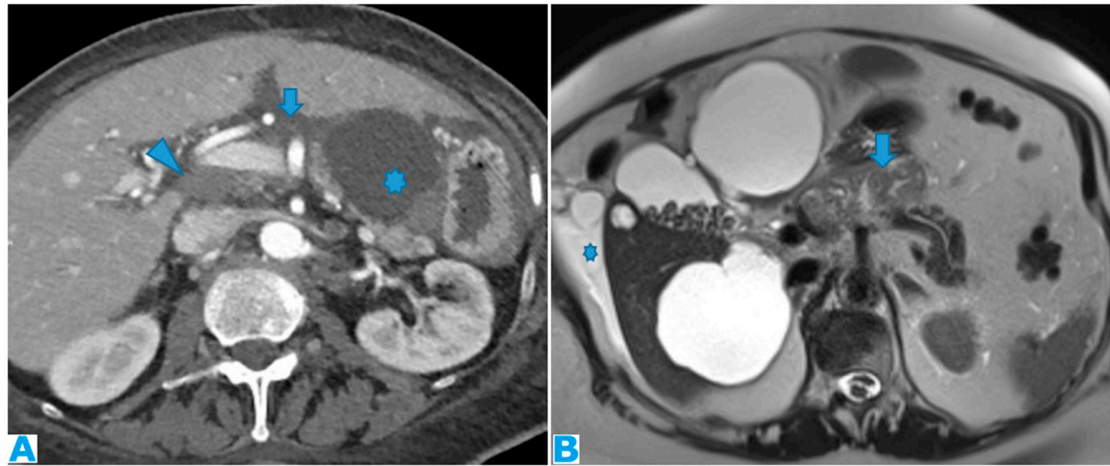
Axial CE-CT (A). PC from ovarian carcinoma: mass-like deposit within the lesser sac (*). Also notice the seeding within the lesser omentum (arrow). Portacaval lymph node (arrowhead). Axial T2WI (B). PC from ovarian carcinoma: mass-like deposit within the lesser sac (arrow). Ascites (*).
